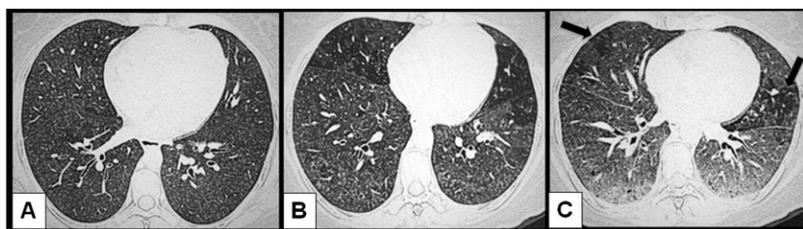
(A) A 40-year-old woman exposed to birds. High-resolution computed tomography (HRCT) scan obtained through lower lungs shows numerous ill-defined nodules. (B) A 53-year-old woman exposed to birds. HRCT images show patchy ground-glass opacities, ill-defined nodules, and patchy areas of mosaic perfusion. (C) Same patient as in B. Expiratory image demonstrating the prominence of the attenuation differences supporting the presence of air trapping (arrows).
